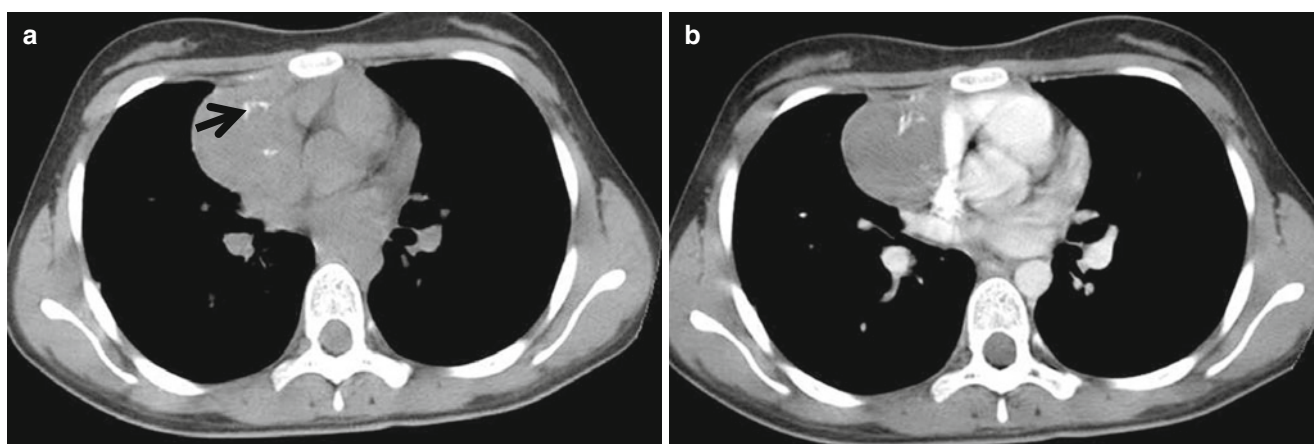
Noninvasive thymoma in a 15-year-old girl. (a, b) Nonenhanced (a) and contrast-enhanced (b) CT show relatively homogenous right thymic mass with calcifications (*arrows*). This mass is a low-attenuating lesion with mild contrast enhancement
